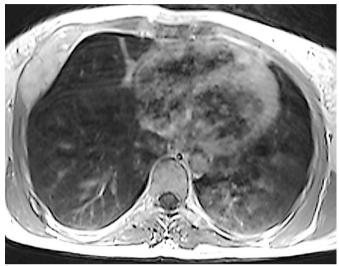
The magnetic resonance imaging of the thorax showed a mass measuring 86x28 mm in diameter in the right anterolateral chest wall
